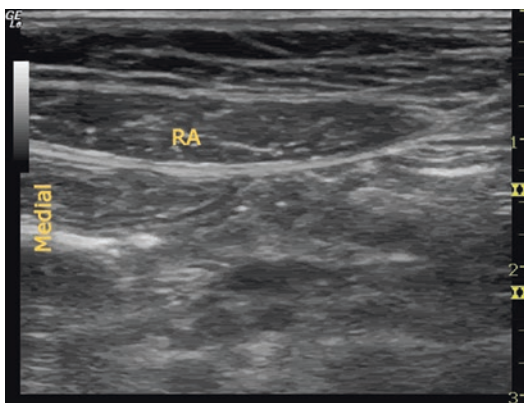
The cross-sectional ultrasonographic appearance of the rectus abdominis
